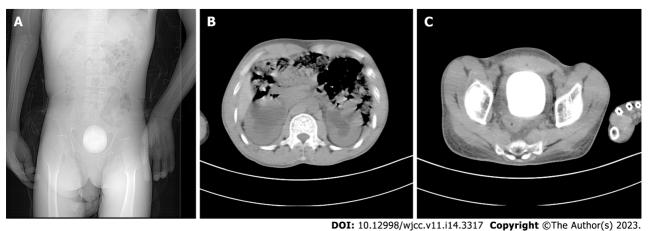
Preoperative abdominal computed tomography findings. A: A large bladder stone; B: Bilateral hydronephrosis; and C: A large bladder stone and thickening of the bladder wall.
